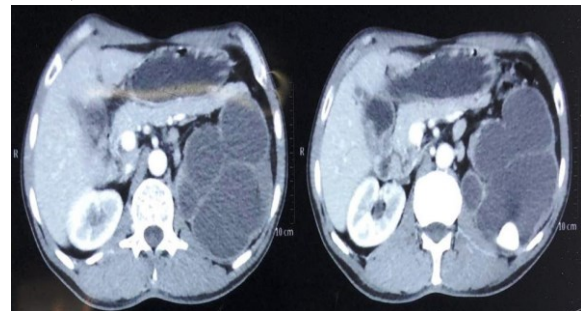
CT IVU showing heterogeneously enhancing lobulated exophytic cystosolid area in left renal pelvis adjacent to calculus with multiple thick internal septations and calcifications.
